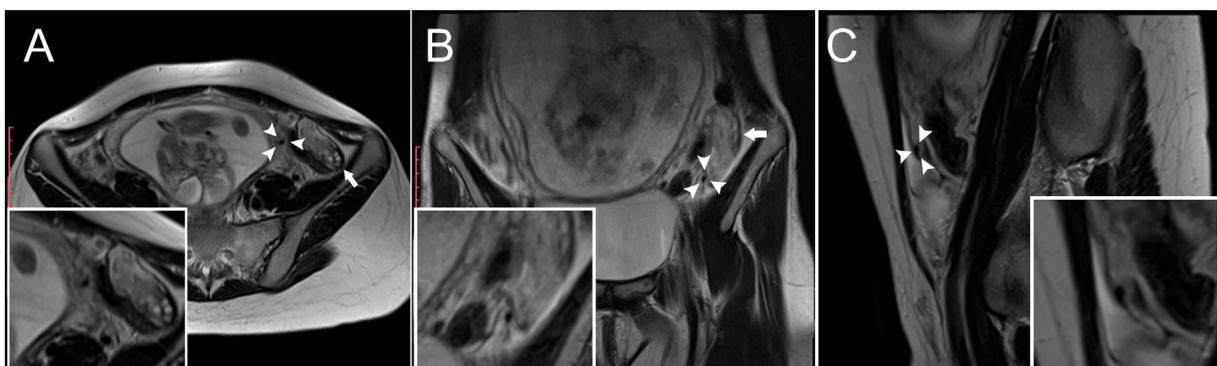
A 28-year-old pregnant woman with left ovarian torsion. Axial (A) sagittal (B), and coronal (C) T2-weighted MR images demonstrate enlarged right ovary (arrows, A and B) and presence of “T2-hypointense dot sign” (arrowheads, A–C). The whirlpool sign could not be identified (false negative).
